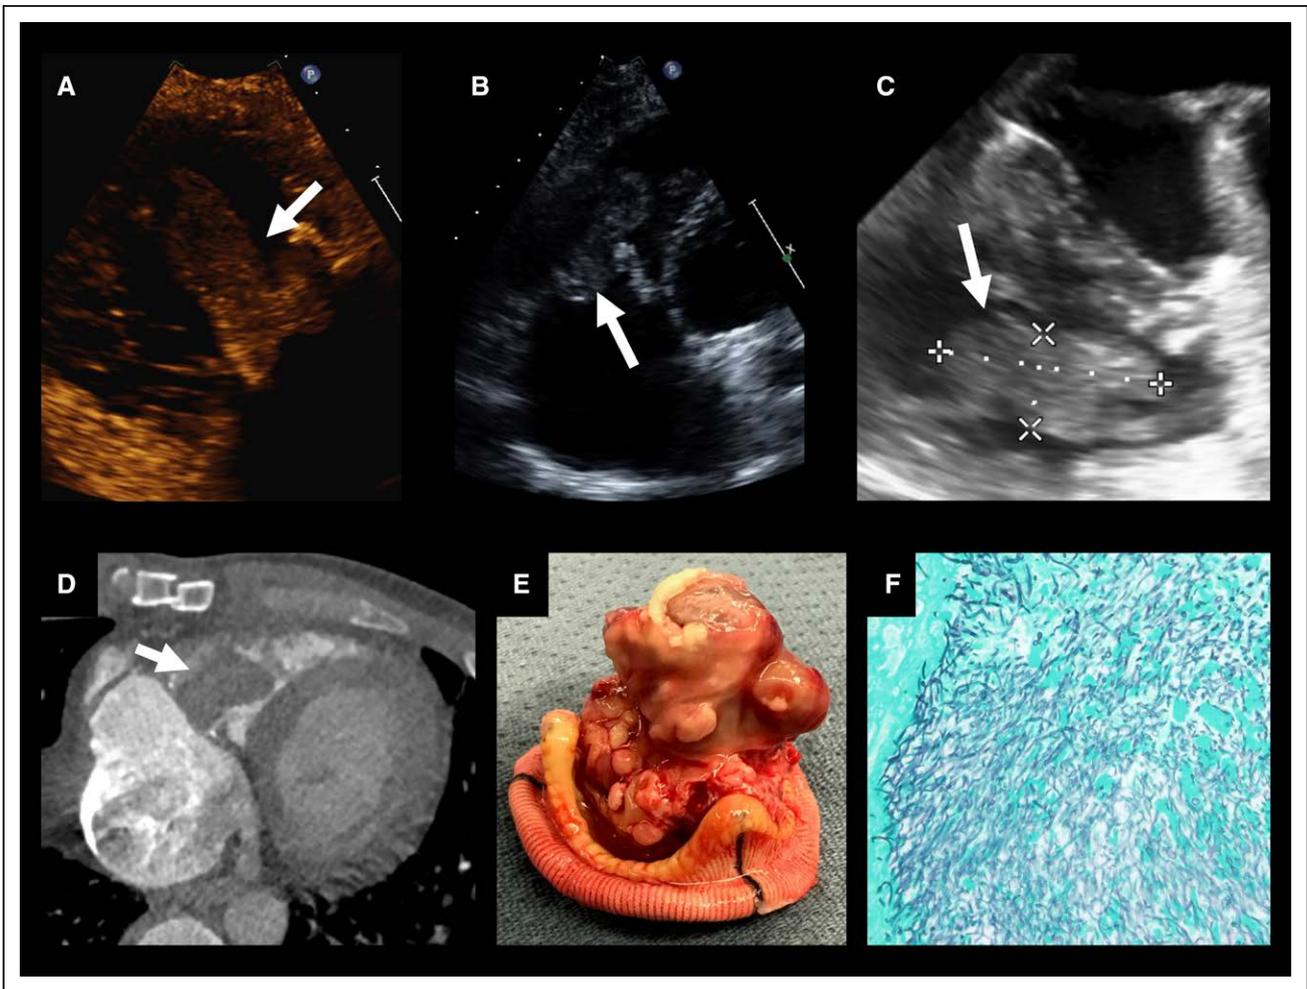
Parasternal long-axis view on transthoracic echocardiography (A) showed a mobile echogenic mass (arrow) on the posterior mitral valve concerning for endocarditis. Transesophageal echocardiography with Doppler studies demonstrated high velocity flow through the mitral valve secondary to inflow obstruction from the mass (B, C). Cardiac magnetic resonance imaging demonstrated a nonenhancing mobile mass in the left atrium with mild peripheral enhancement (D). Pathology of the mitral valve revealed acute fungal endocarditis with septated, acute-angle branching hyphal forms consistent with *Aspergillus*. Extensive valve tissue destruction was also present (E).
